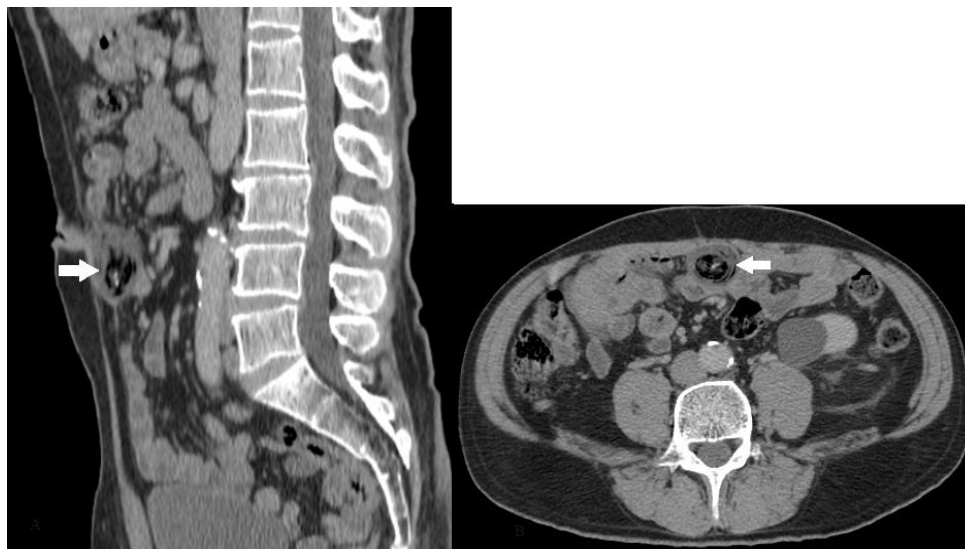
Sagittal and axial images of contrast-enhanced CT scan showing well defined heterogeneous mass (arrow) with anterior location situates just beneath the umbilicus; containing fat and few calcifications.
